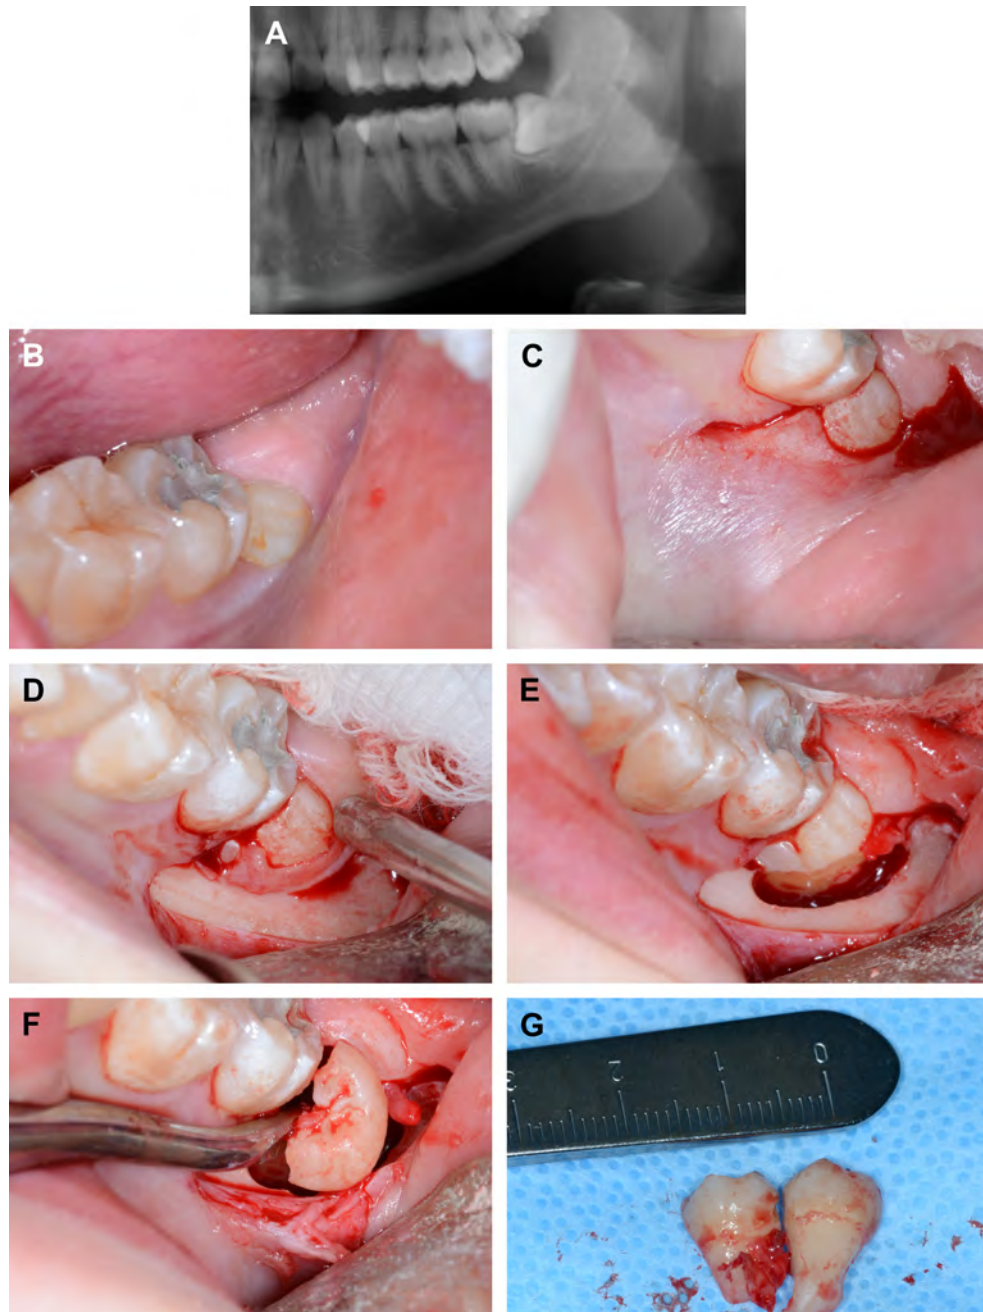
(A) Radiograph of horizontal impacted left mandibular third molar. (B) Horizontal impacted left mandibular third molar. (C) Envelope flap with anterior vertical releasing incision. (D) Soft tissue reflected to access third molar site. (E) Buccodistal bone trough made adjacent to crown with fissure bur. (F) Crown sectioned in half, superior half along with root removed first. (G) Inferior portion of crown removed after superior half.
